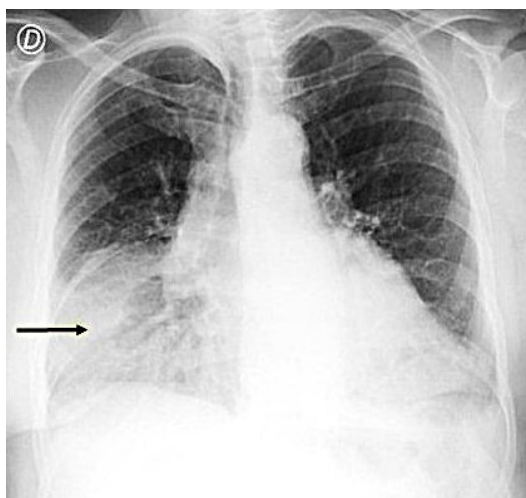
Frontal chest radiograph showing a heterogeneous paracardiac opacity in the lower right hemithorax (arrow).
